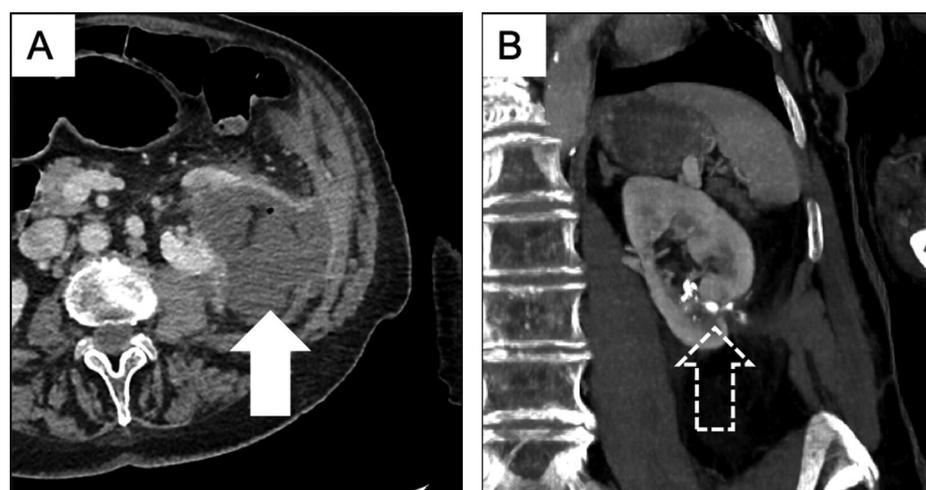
79-year-old woman presenting with urinary fistula after percutaneous cryoablation of a renal cell carcinoma of the left kidney. A. CT image in the axial plane shows urinoma (arrow). B. Follow-up CT image in the coronal plane 10-months after glue plugging shows complete resolution of the fistula. Dashed arrow shows the cyanoacrylate glue plug.
